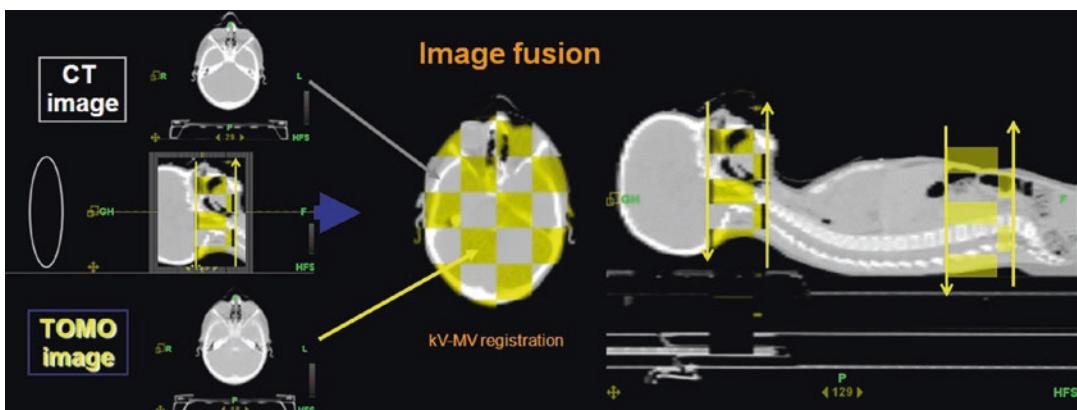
Daily pre-treatment MVCT setup acquisition in a patient who underwent CSI. Daily megavoltage computed tomography (MVCT) scans were performed for setup purposes in a medulloblastoma patient. MVCTs were typically acquired before each fraction allowing a daily patient setup verification and correction. The scan
